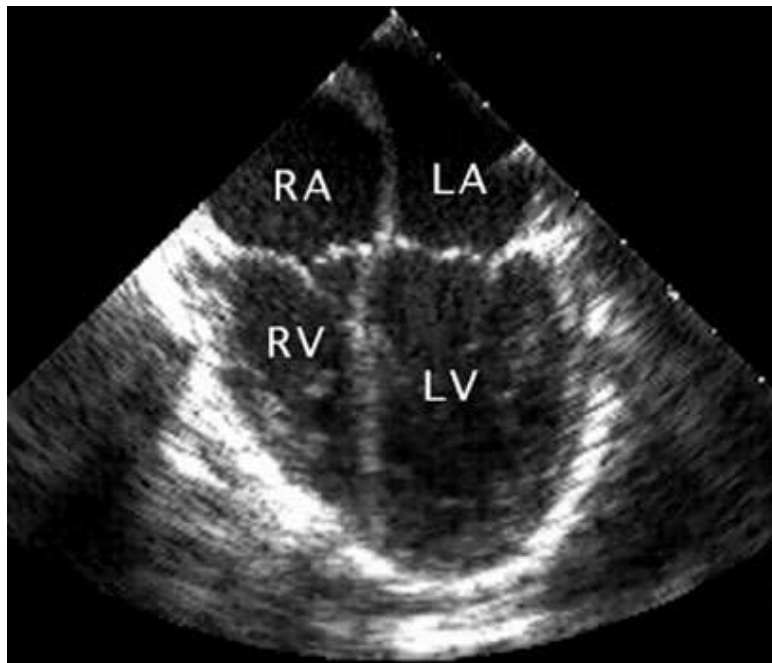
Four-chamber echocardiogram rarely reveals the apex of the left ventricle (LV), estimates of filling and ejection derived from these cross-sections usually underestimate LV end-diastolic volume and overestimate ejection fraction. This cross-section is often the best for detection of right ventricular (RV) dysfunction (Cahlan, 1997).
